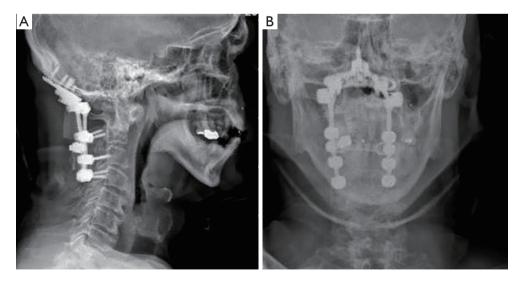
Immediate postoperative radiographs demonstrating occiput to C4 fusion.
